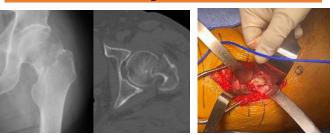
AP Hip X-ray and axial CT demonstrating a displaced left femoral neck fracture.
